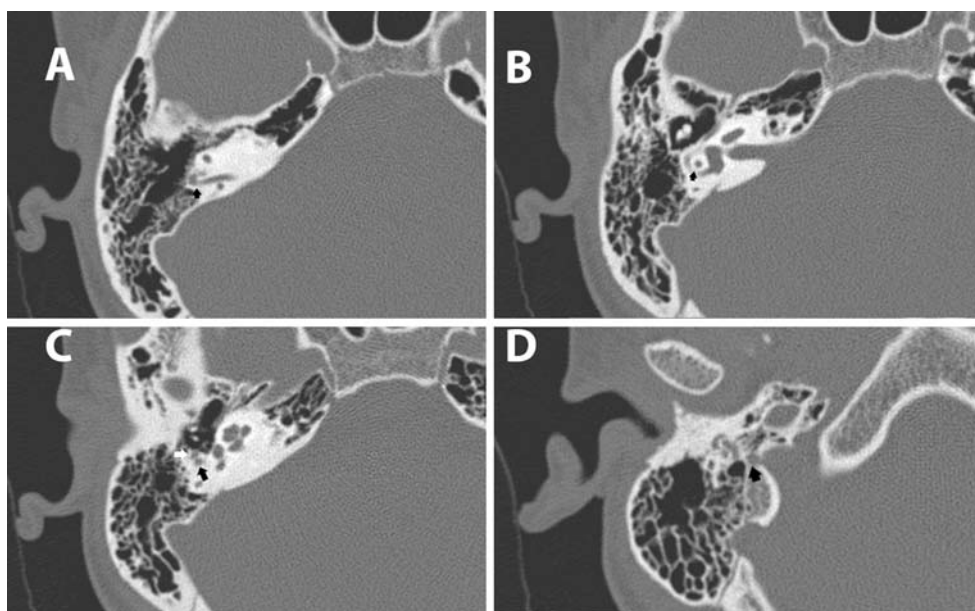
(Axial HRCT-scan). a Proximal tract of the intratemporal portion of the SAA (*arrow* indicates a kinking of the canal), b Course of the artery in the middle of the arches of the LSC, c Close relationship of the SAA (*black arrow*) to the mastoid tract of the Fallopian canal (*white arrow*), d Distal tract of the SAA opening toward the jugular foramen
